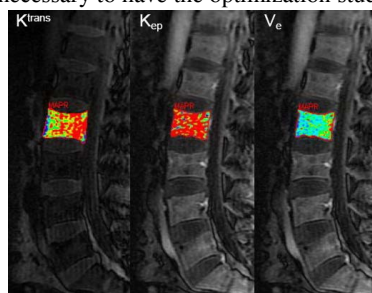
DCE-MRI: The  $K^{trans}$ ,  $K_{ep}$  and  $V_e$  map of L2.
